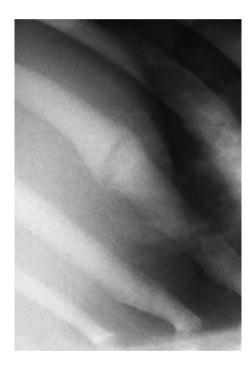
Case 1: fracture-like abnormality of posterior part of the left 10th rib at age 34 months. The appearance of this lesion had not changed in several radiographs over the preceding 4 weeks and was thought to be a pseudofracture.
